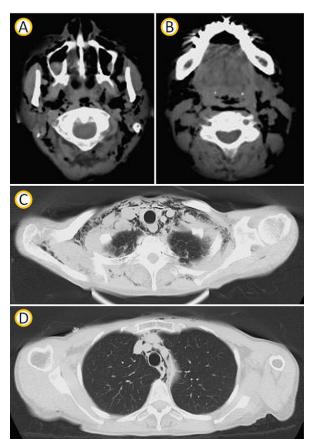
Computed tomography scan of the thoracocervicofacial region shows widespread emphysema from the cervicofacial space, including the buccal, masticator, submandibular, parapharyngeal, and retropharyngeal spaces (A, B), to the mediastinum (C) and precordium (D).
